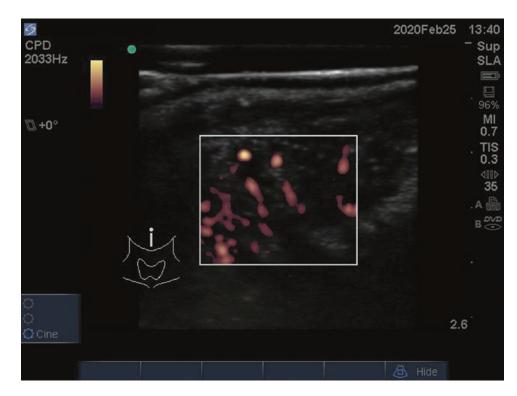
Example of Power Doppler examination of the tongue
